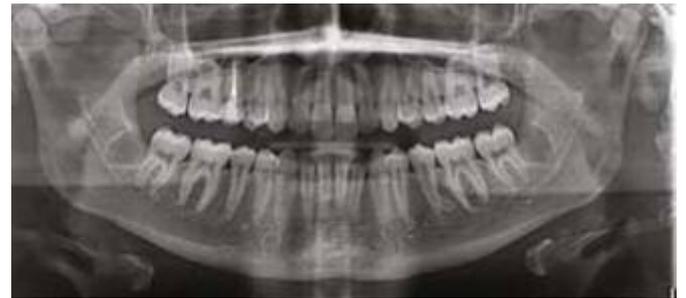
Final orthopantomography
